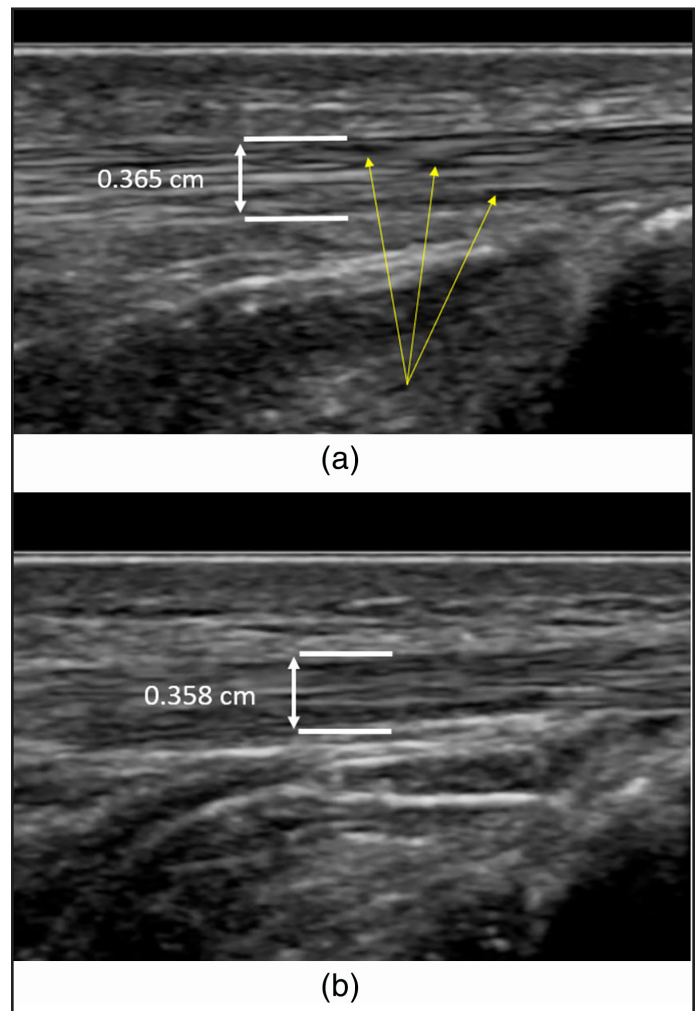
(a) Sonographic Image of Athlete 2's Left Patellar Tendon (Baseline). Arrows pointing to hypoechoic region. Tendon thickness 0.365 cm. (b) Sonographic Image of Athlete 2's Right Patellar Tendon (Baseline). Tendon thickness 0.358 cm.
